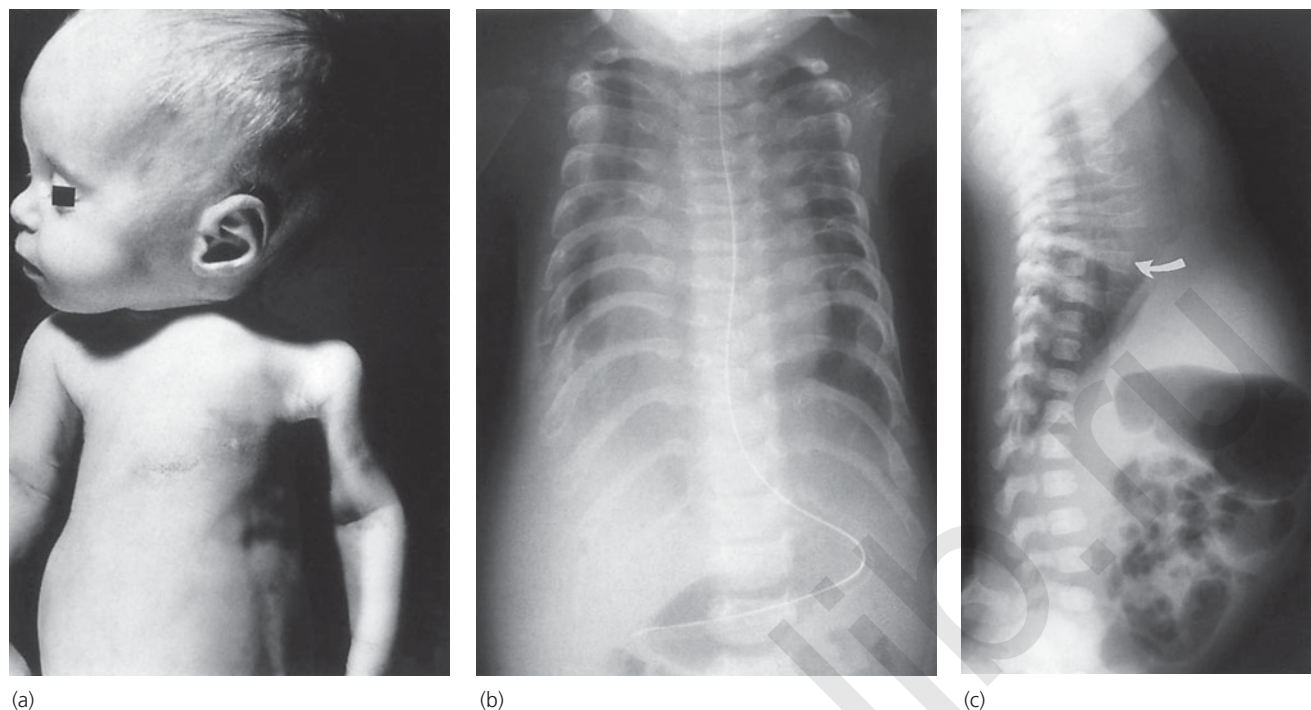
Infant with asphyxiating thoracic dystrophy (Jeune syndrome). (a) Clinical photograph demonstrates small size of thorax relative to infant. (b) X-ray shows the short horizontal ribs and narrow thorax with limited lung volumes. (c) Lateral x-ray demonstrates the ends of the bony ribs at the mid-axillary line and the abnormal costochondral junctions (arrow).
